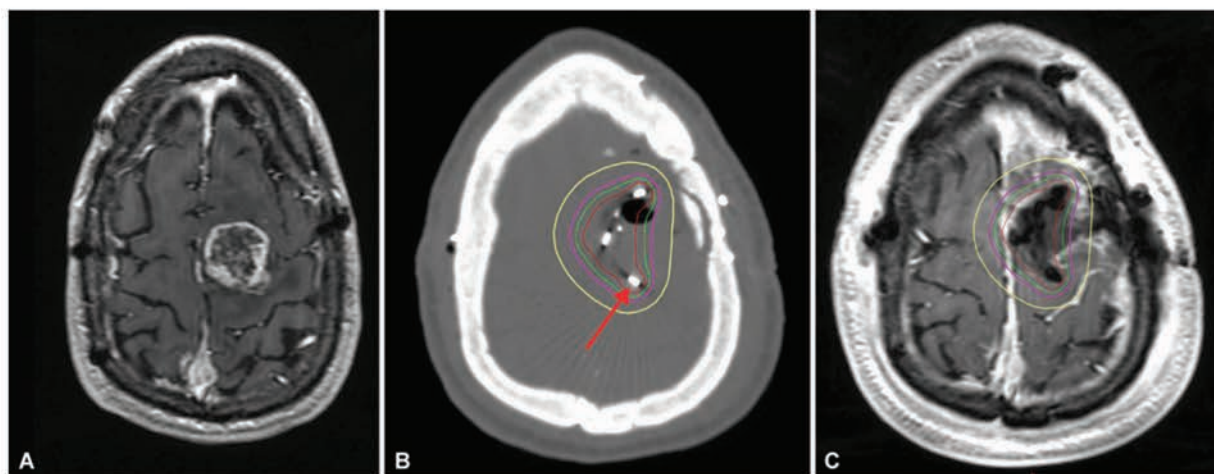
Patient 3. A: Preoperative axial postcontrast T1-weighted MR image. B: Postoperative axial CT image showing dosimetry with 30- (yellow), 60- (magenta), 80- (green), and 120-Gy (red) isodose lines, and Cs-131 seeds (arrow). C: Postoperative axial postcontrast T1-weighted MR image with isodose lines as described in B and seeds appearing as small areas of signal void.
